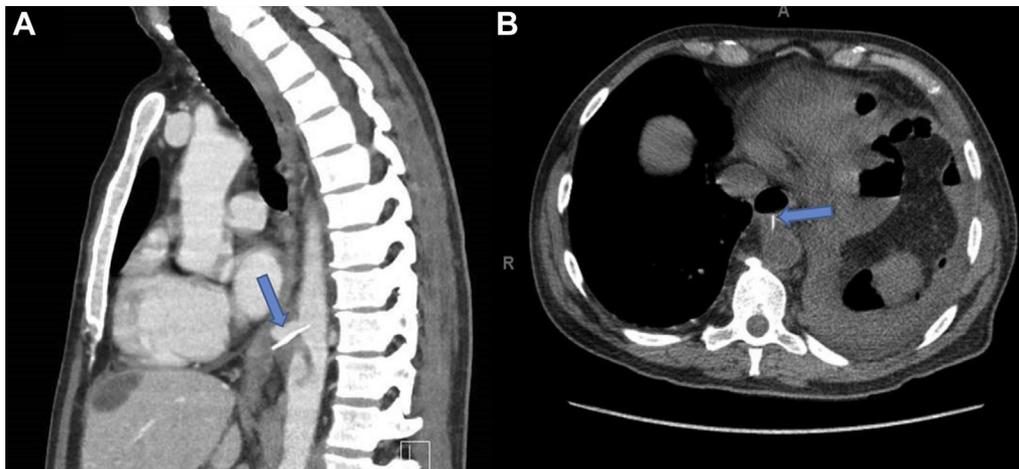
Preoperative computed tomography scan of the chest showing the metallic foreign body on sagittal (A) and axial (B) views.
